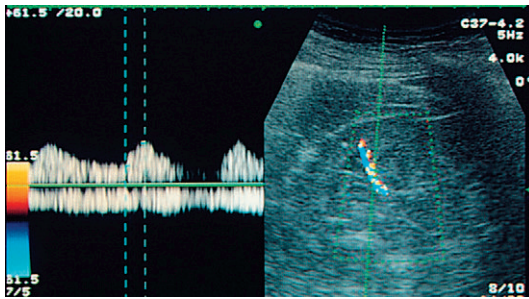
Colour box reduced in size to demonstrate single intrarenal vessel prior to sampling for spectral Doppler.
